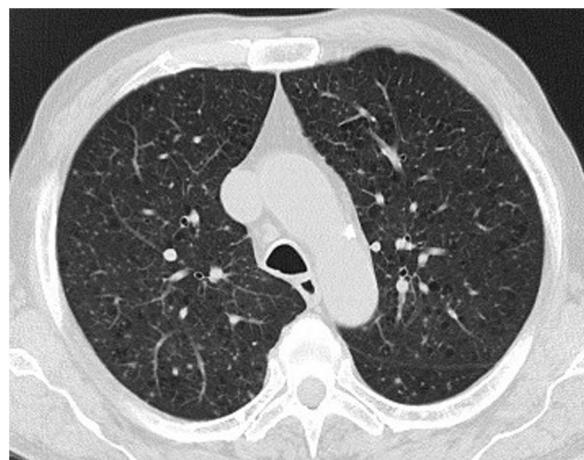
Thoracic CT scan showing pulmonary nodules in a miliary pattern.
